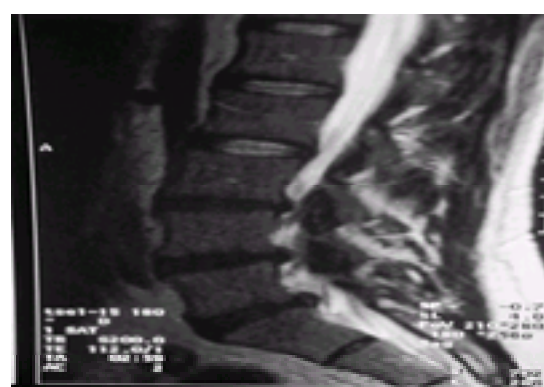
MRI of dark disc, consistent with degenerative disease.
